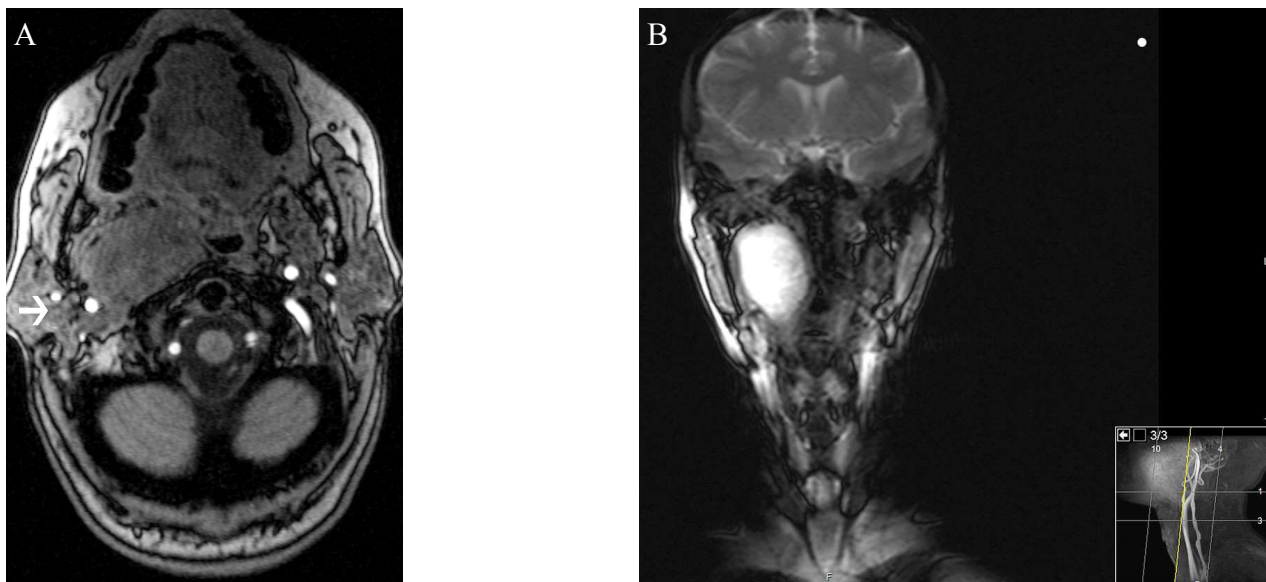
MRI showing lateral and posterior displacement of both the internal and external carotid arteries (white arrow). Figure 1b: Angio-MRI showing no vascular involvement of the tumor.
